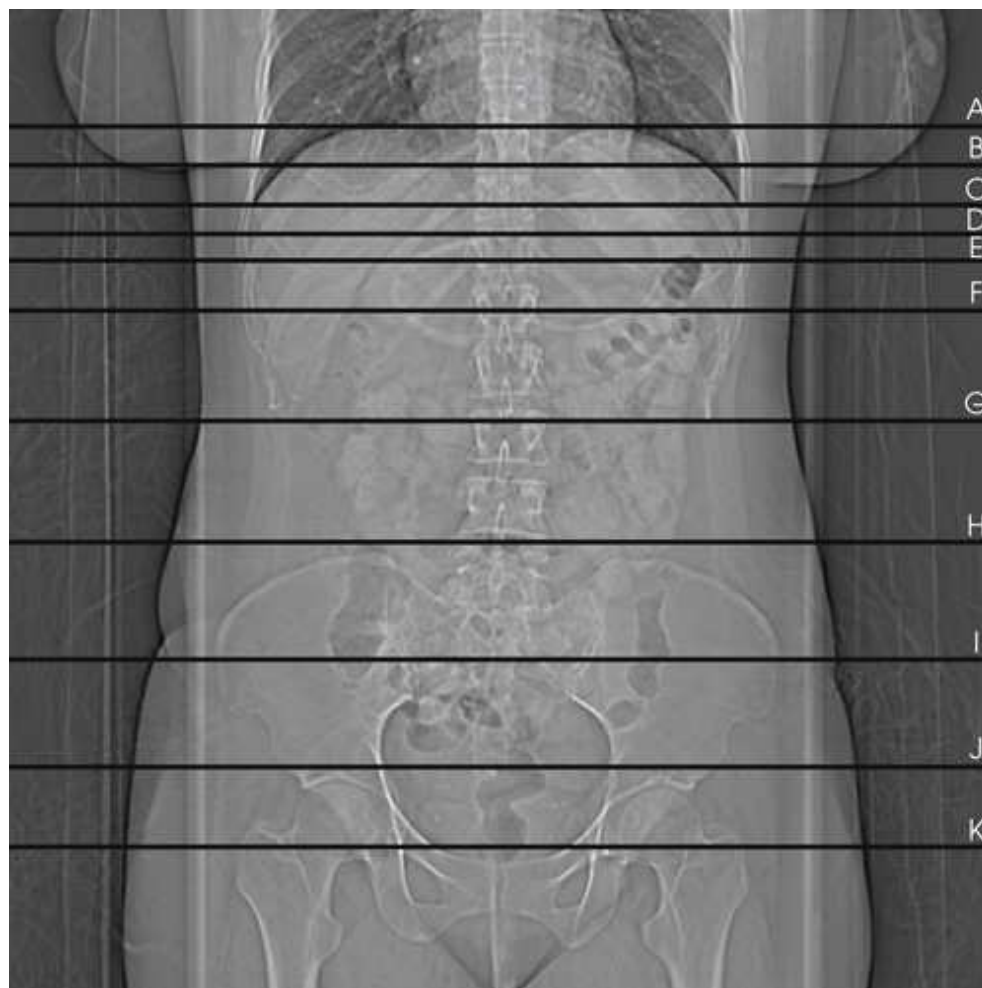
CT localizer (scout) image of abdominopelvic region.
